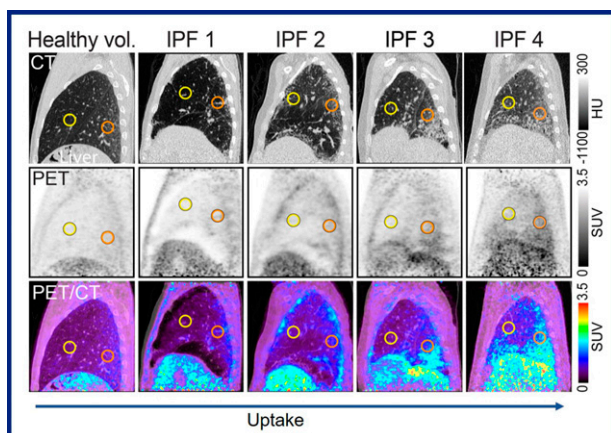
^{64}Cu PET/CT in patients with idiopathic pulmonary fibrosis (IPF). Top row: CT; middle row: PET; bottom row: PET/CT in (left) a healthy volunteer and 4 patients with IPF.
